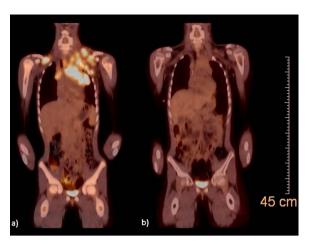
Functional imaging with 18F-fluorodeoxyglucose (18F-FDG) PET in a child with Hodgkin's lymphoma. (A) 18F-FDG PET pretreatment. (B) 18F-FDG PET after two cycles of OEPA chemotherapy (vincristine, etoposide, prednisolone, doxorubicin).
